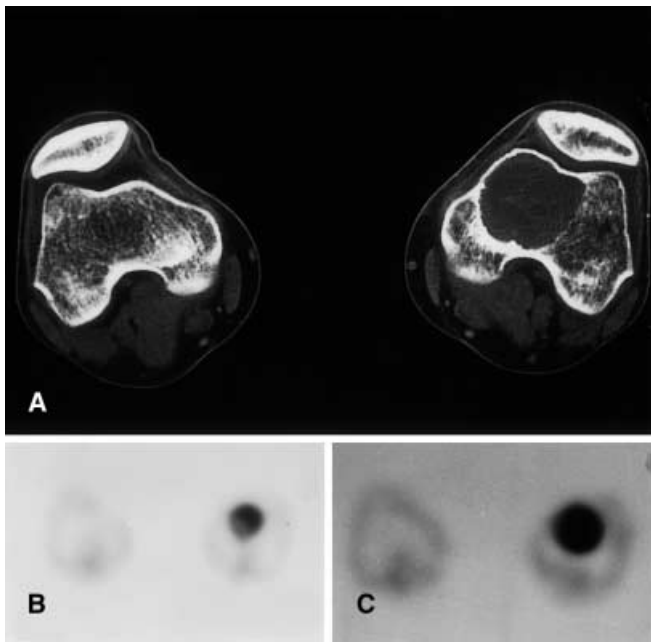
A 30-year-old male (KY) with a giant cell tumour of the medial condyle of the femur. A CT scan shows extensive destruction of the marrow space and expansion of the cortex with preservation of continuity. B FMT-PET scan demonstrates uniformly increased uptake through the lesion. The SUV was 0.94, indicative of a benign lesion. C An FDG-PET scan shows markedly increased accumulation in a similar uniform pattern with an SUV of 3.2, suggesting a malignancy
